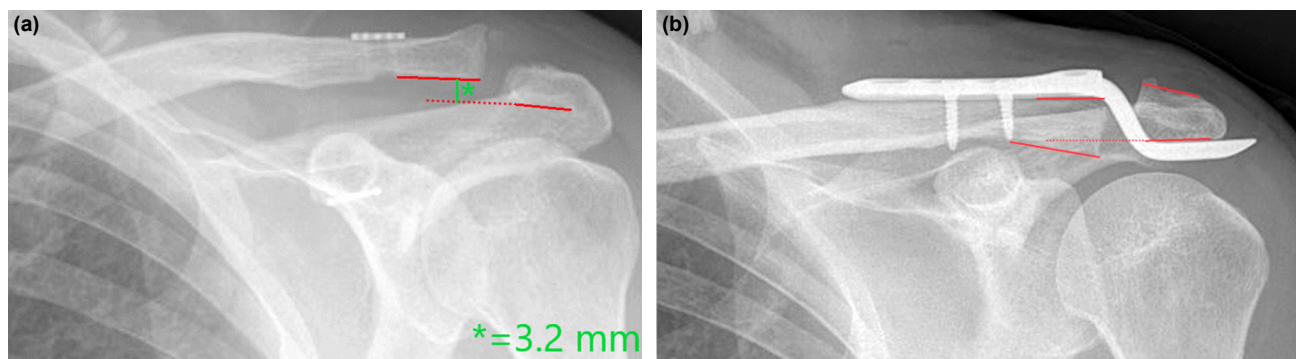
The early post-operative Zanca views of patients with under correction (a) and overcorrection (b). Overcorrection was defined if the inferior border of the clavicle is below the inferior border of the acromion. In contrast, under correction is determined if the clavicle's inferior border is above the acromion's inferior border and the vertical distance between them is more than 2 mm on the early post-operative radiographs.
